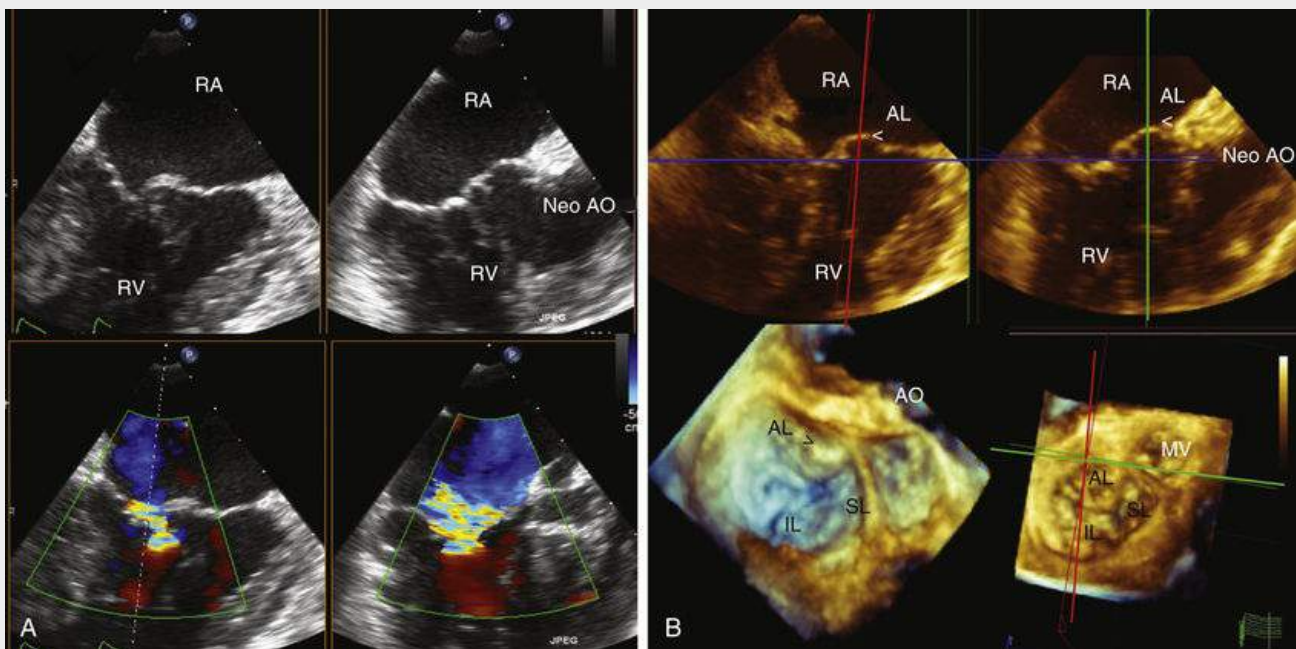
Three-dimensional tricuspid valve following Fontan procedure. The TEE image labeled A demonstrates moderate tricuspid valve regurgitation following a Fontan procedure in a patient with hypoplastic left heart syndrome and dextrocardia. Although the moderate regurgitation is evident from the color Doppler signal, the precise mechanism and location are unclear. The real-time 3D echocardiography image labeled B displays the tricuspid valve in the MPR mode (multiplane reformatting), as well as a surgical en face view of the tricuspid valve. The *red* and *green lines* are at right angles to each other and show that the main problem is prolapse of the anterior leaflet of the tricuspid valve. The lower right-hand image is taken in the exact same spatial location as the upper two images; the lower left-hand image has been angled to show the prolapse in more detail. Although not seen from the surgical en face view, the position of the aorta has been noted to help with orientation. AL, anterior leaflet; AO, aorta; IL, inferior leaflet; MV, mitral valve; SL, septal leaflet.
